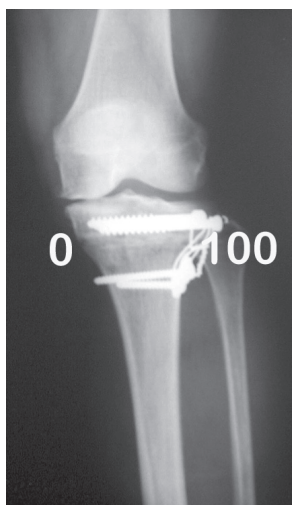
Postoperative X-ray image at anteroposterior plane showing alignment on the anatomical axis and fixation with screws and “eight-shaped” ties.
